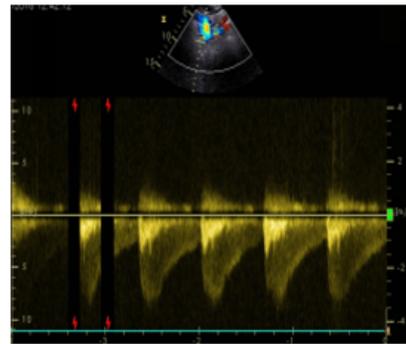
Supra sternal view continuous doppler quantifying the isthmic aortic gradient.
